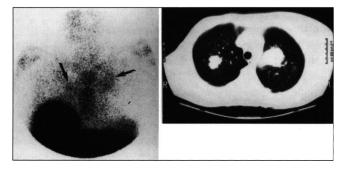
Planar anterior chest view (left) obtained 24 hr postinfusion of 30 mCi ^{99m}Tc-CEA-Scan[®] in the same patient as in Figure 2. The scan demonstrates clear evidence of lung metastases seen by CT (right) in both upper lobes of the lungs, despite high CEA level in the patient (2592 ng/ml) and 47% antibody complexation with the circulating antigen.
